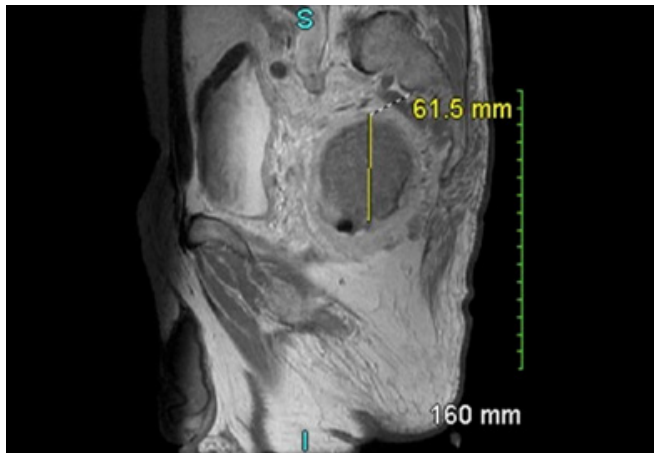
Abdomen/pelvis MRI showing the rectal mass with a height of 61.5 mm.
